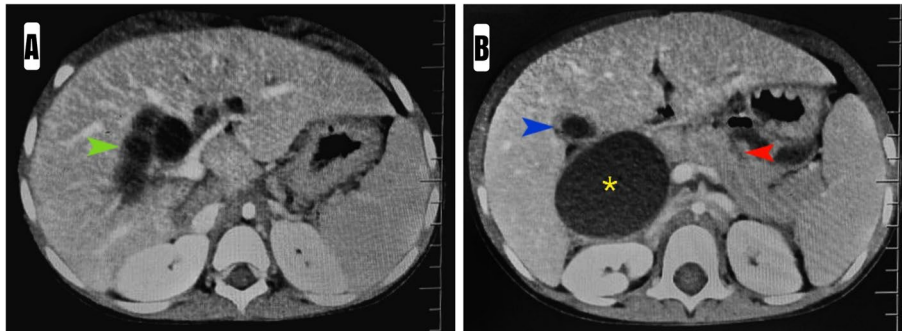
A and B: Preoperative axial CT scan of the abdomen showing (A) multiple intrahepatic biliary radicle dilatations (green arrowhead) and (B) a giant cystic dilatation of the common bile duct (yellow asterisk). The main pancreatic duct (red arrowhead) and GB (blue arrowhead) are unremarkable
